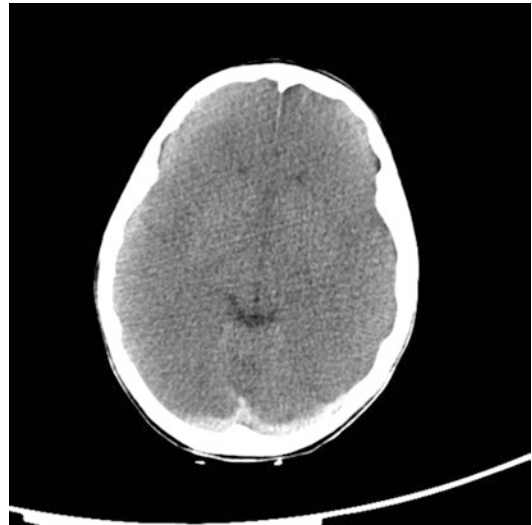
Cerebral autolysis at CT scan image
